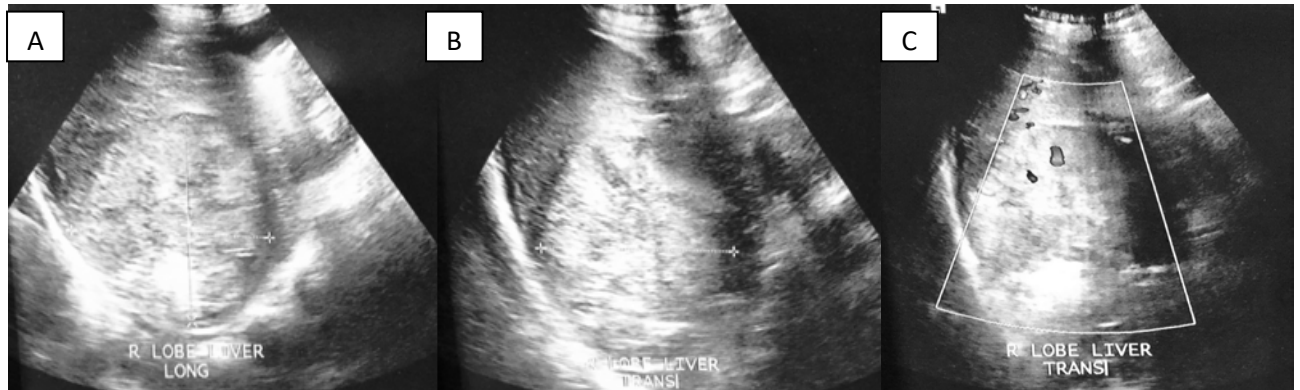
Ultrasound of the Whole Abdomen focused on the liver (A to C): Solid mass at Segment VI/VII of the right hepatic lobe showing minimal intralésional vascularity in color Doppler (C)
